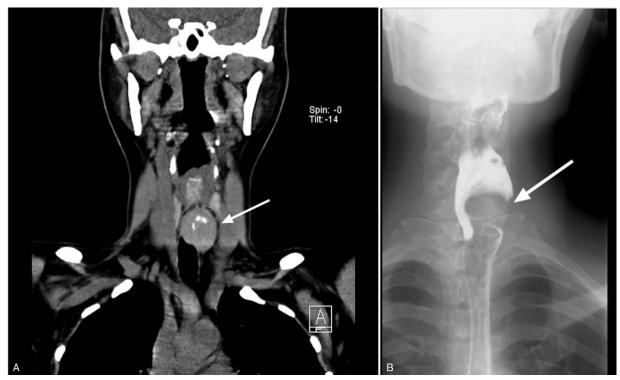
Computed tomography and barium meal findings of the lesion. (A) Computed tomography of the neck demonstrated a soft tissue mass(arrow) measuring 27 × 25 mm posterior to the lower pole of the left thyroid gland with coarse calcifications; (B) A space occupying lesion(arrow) with smooth margin was shown by barium meal of the esophagus.
